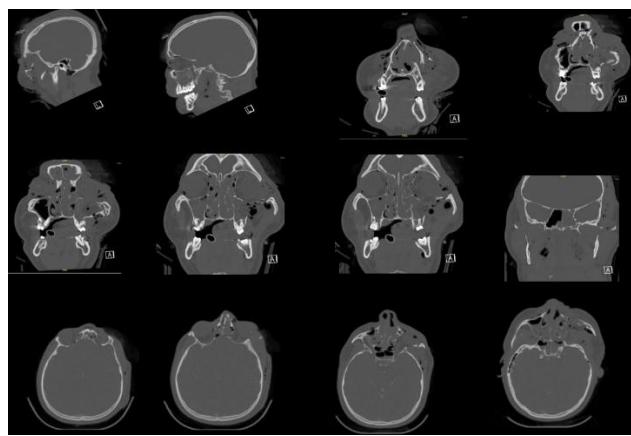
CT of axial, coronal, and sagittal planes.
